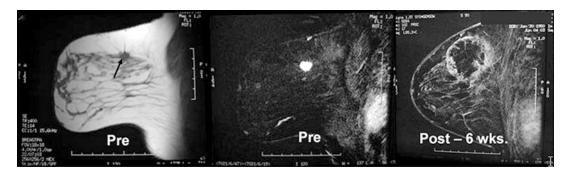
Pre-cryotherapy MRI – multifocal left upper outer quadrant cancer: Left: T1-weighed axial image shows the spiculated, 1.6-cm dominant mass in the left outer quadrant (black arrow). Another biopsy confirmed cancer in the same quadrant was in different image planes. Middle: Fat-subtracted T1-weighted image following gadolinium (T1FS-Gd) showing brisk tumor enhancement. Right: T1FS-Gd image showing rim of enhancement corresponding to healing cryotherapy rim which also covered the other cancer. The micro-lumpectomy sampling
